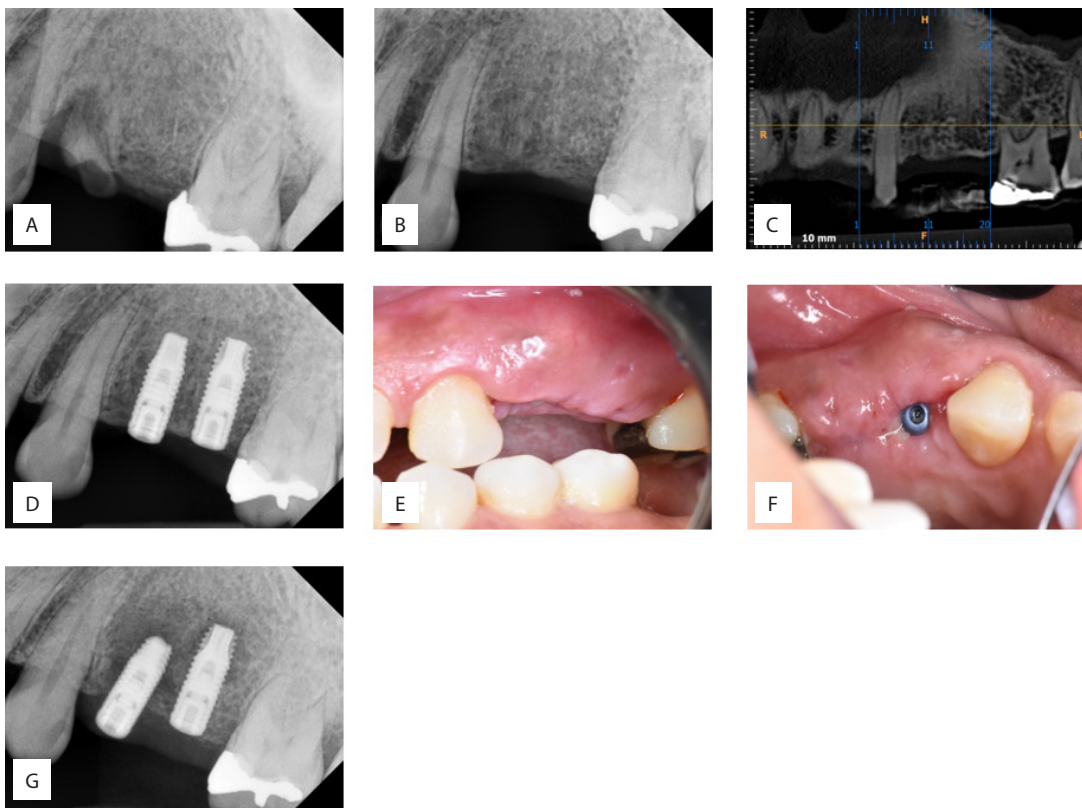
(A) Periapical radiograph of retained root tooth 24 and edentulous region of tooth 25 shows no pathological periapical lesion; (B) Periapical radiograph of edentulous region of tooth 24 and 25 shows no abnormalities at 10 months after extraction of retained root tooth 24; (C) CBCT of radiographic stent shows no pathological radiolucency; (D) Periapical radiograph of implant 24 and 25 after placement shows no abnormal radiolucency; (E) Clinical (buccal) view at three weeks shows ill-defined swelling on buccal attached gingiva of tooth 24 edentulous region; (F) Clinical (occlusal) view at three weeks shows almost full exposure of cover screw on implant 24 with pus on the distal; (G) Periapical radiograph of implants 24 and 25 shows periapical radiolucency noted on implant 24 extending to mesial of implant 25 6×5 mm in diameter.
